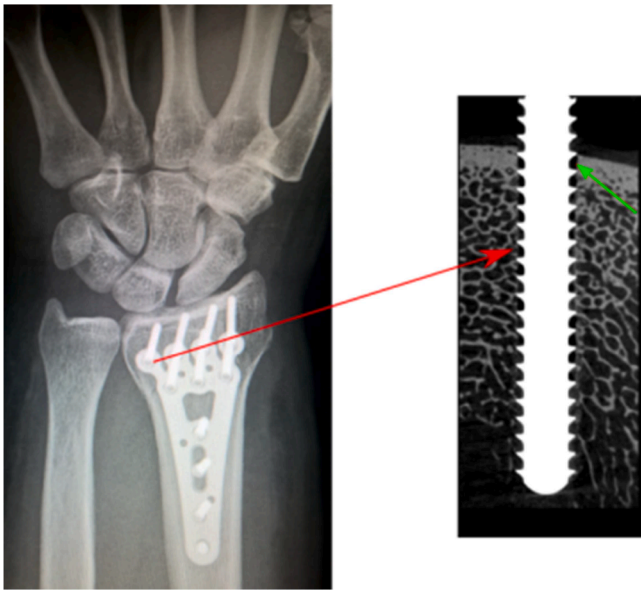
X-ray image of a distal radius fracture treated with osteosynthesis plate. Close up image shows poor contact between the implanted screw and bone marked by a green arrow.
